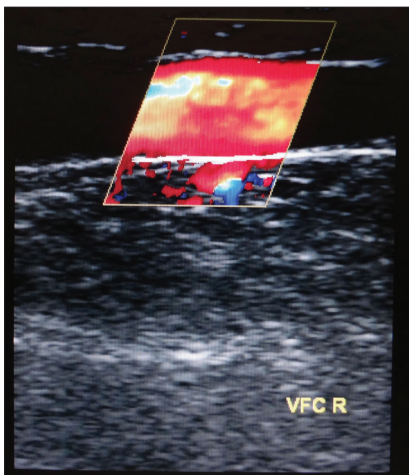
Incompetent GVS (duplex ultrasound)
